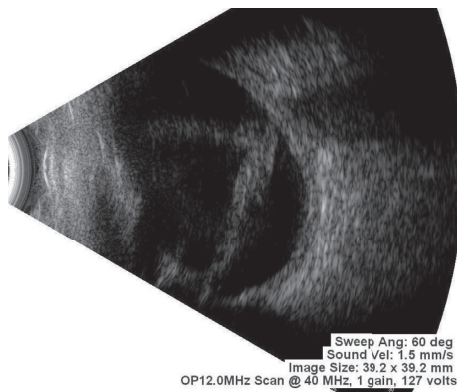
Ultrasonography (B-scan) report suggestive of membranous echoes in vitreous cavity with restricted movements and attachment to optic disc is suggestive of open funnel retinal detachment.
